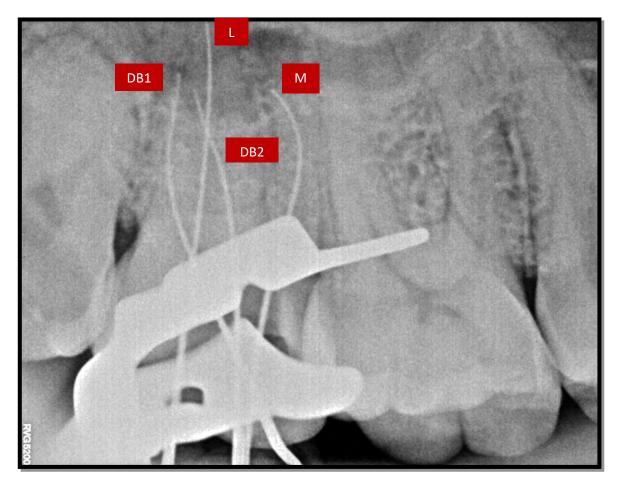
(Radiograph of files in the mesiobuccal, two distobuccal, and palatal root canals which were found.)
